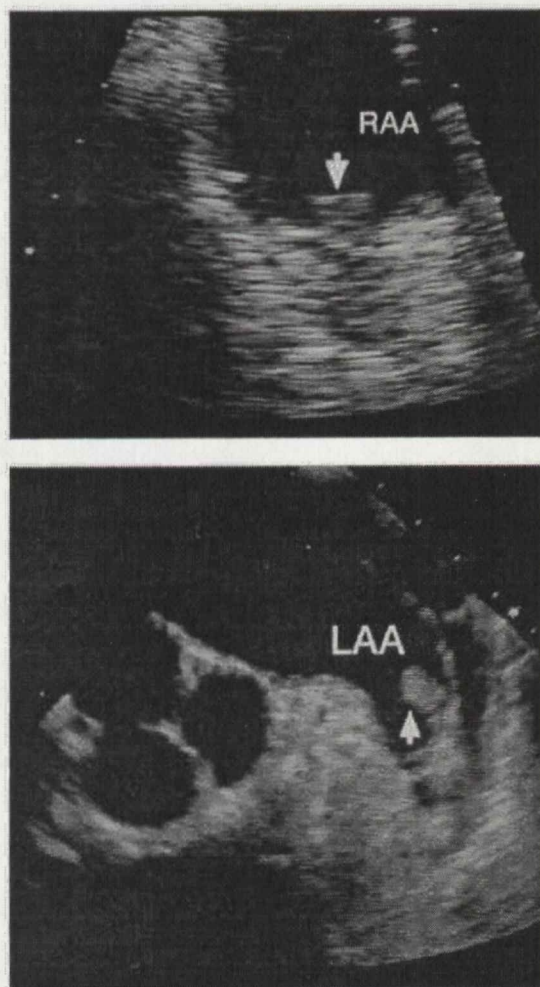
Transesophageal Echocardiograms. Top. An 8.5 mm protruding thrombus (arrow) in the right atrial appendage (RAA) of a 53-year-old man. Bottom. A 9 mm LA appendage (LAA) thrombus (arrow) in a 70-year-old man.
